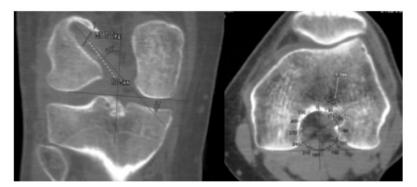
Femoral tunnel coronal obliquity and modified clockwise position on CT.
